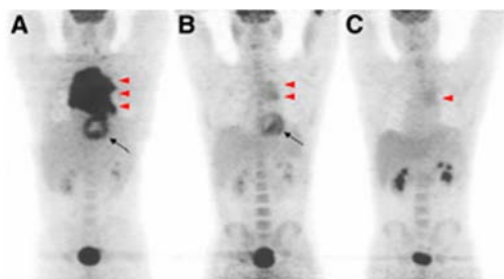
PET-CT OF 40 years old patient showing mediastinal mass
